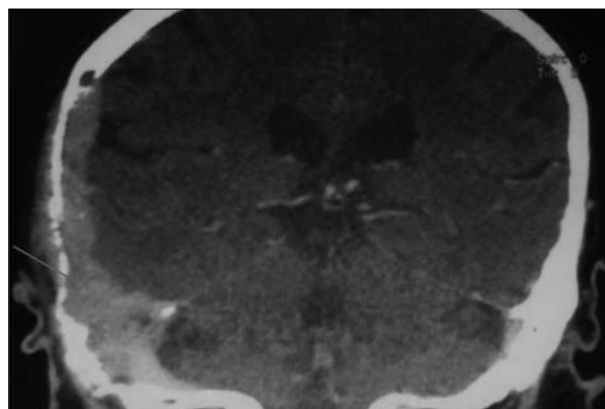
Coronal view of the computed tomography scan: progressive metastatic breast cancer after chemotherapy treatment (arrow)
